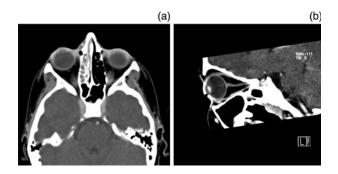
(a) Axial and (b) parasagittal CT scan slices of the orbit. No orbital collection evident.
